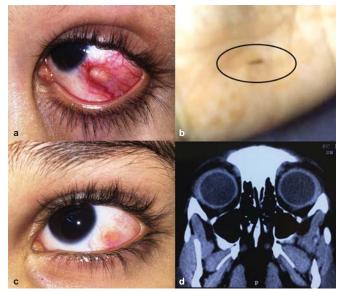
The child at presentation with a 3 mm×3 mm nodule at the inferotemporal aspect of the eye located 3 mm from the limbus (a). The nodule showed overlying conjunctival congestion with dilated episcleral vessels. A wooden foreign body (about 2 mm in length) spontaneously extruded out of the eye, picture of which was captured by the mother of this child in her phone (b). The redness reduced and the nodule flattened after foreign body extrusion (c). Non-contrast computed tomography scan done after foreign body extrusion was normal (d)
